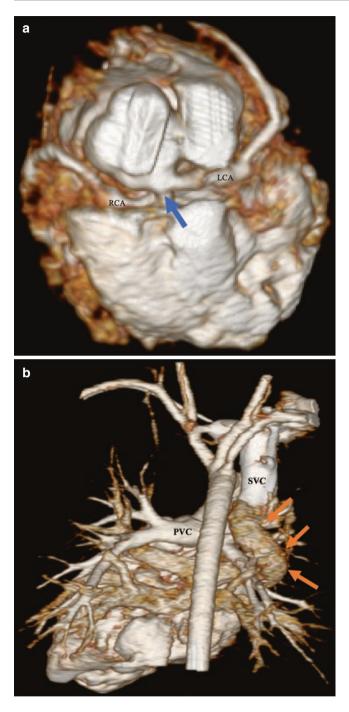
Volume-rendered 3D reconstruction of cardiac CTA in a 5-day-old male with DORV. The high spatial and temporal resolution of cardiac CTA can be used to define coronary anatomy (a) such as the anomalous common coronary origin (arrow) originating from the posteriorly directed cusp of a quadricuspid aortic valve before dividing into the right (RCA) and left (LCA) coronary arteries. Additionally, complicating extracardiac anatomy such as total anomalous pulmonary venous return (b) vertical vein (orange arrows) connecting the confluence of pulmonary veins (PVC) to SVC can be readily demonstrated
